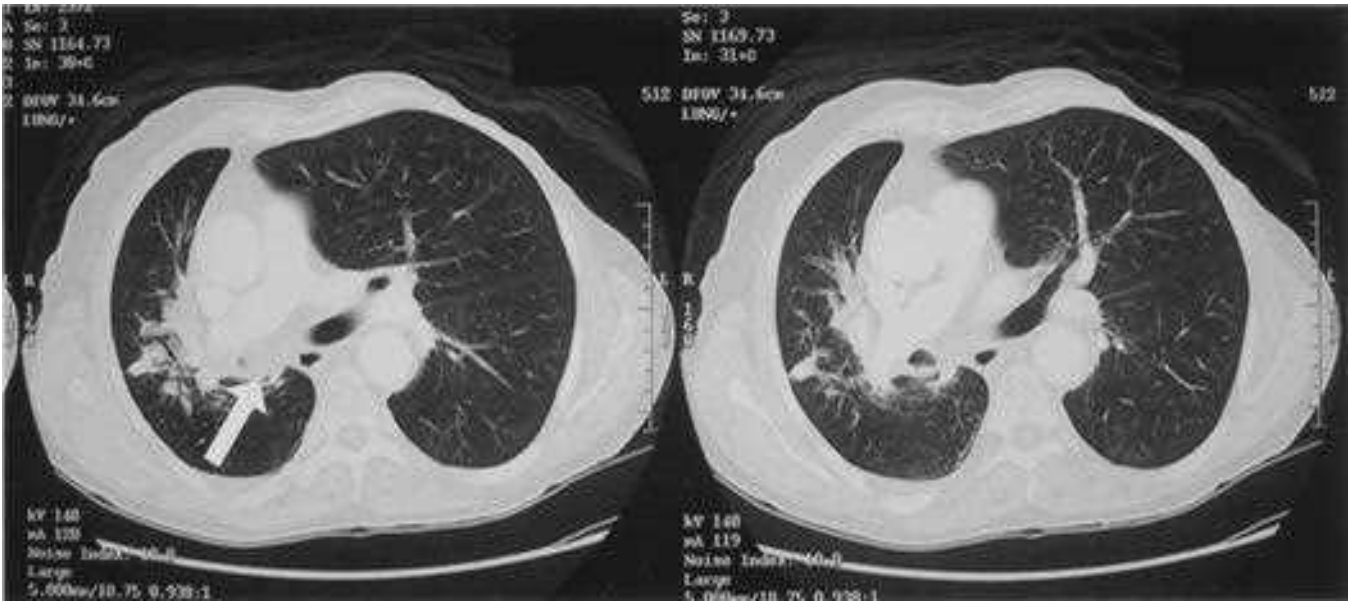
Chest computed tomography scan of an obstructing right main stem lung tumor. *Arrow* indicates location of right main bronchus. The right lung volume is much less than the left lung volume.
